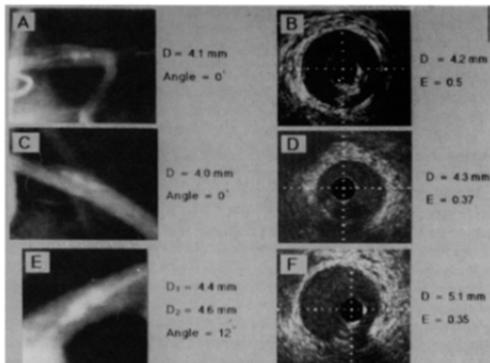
A, Ultrasound catheter parallel to vessel long axis and centered in lumen with (B) corresponding ultrasound image. C, Ultrasound catheter parallel to vessel long axis and eccentric in lumen with (D) corresponding ultrasound image. E, Ultrasound catheter at angle to vessel long axis and eccentric in lumen with (F) corresponding ultrasound image. D = diameter; E = eccentricity index.
